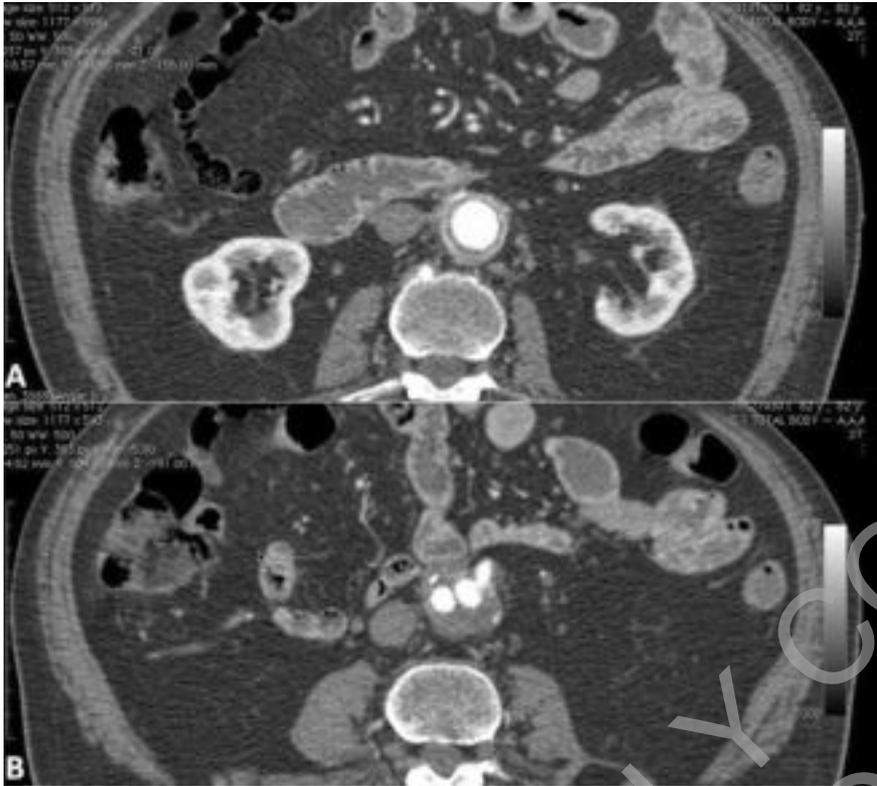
A, B: Contrast-enhanced axial computed tomography examination shows aorto-prosthetic anastomosis (A) and a retrograde bypass from the left prosthetic leg to the inferior mesenteric artery (B).
